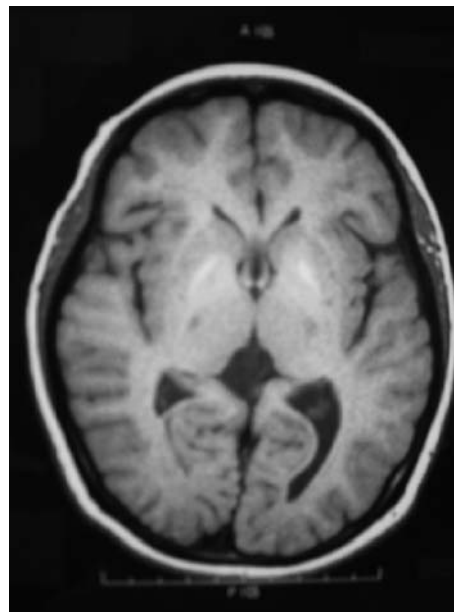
High intensity areas in the bilateral globus pallidus were noted on T1-weighted magnetic resonance imaging
